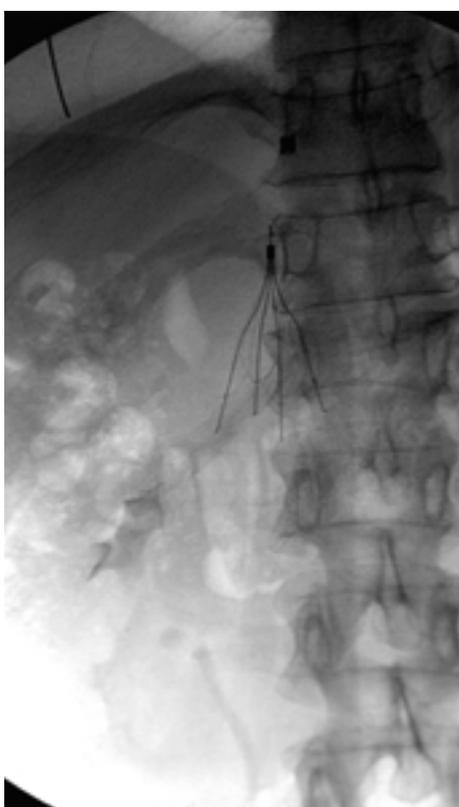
Digital radiograph demonstrates deployed Günther tulip filter at the level of suprarenal IVC.
